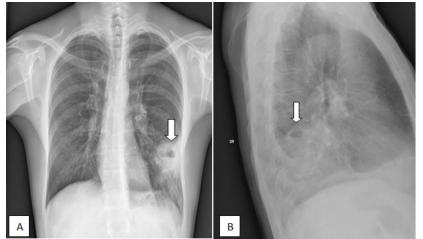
A - patient aged 65 years, chest radiograph posterior-anterior incidence - cavity image with thick wall and horizontal hydro-aerial level projected left basal; B - patient aged 60, chest radiograph lateral incidence - opacity with hydro-aerial level projected at the apical region of the lower right lobe. Note: white arrow () - opacity with hydro-aerial level.
